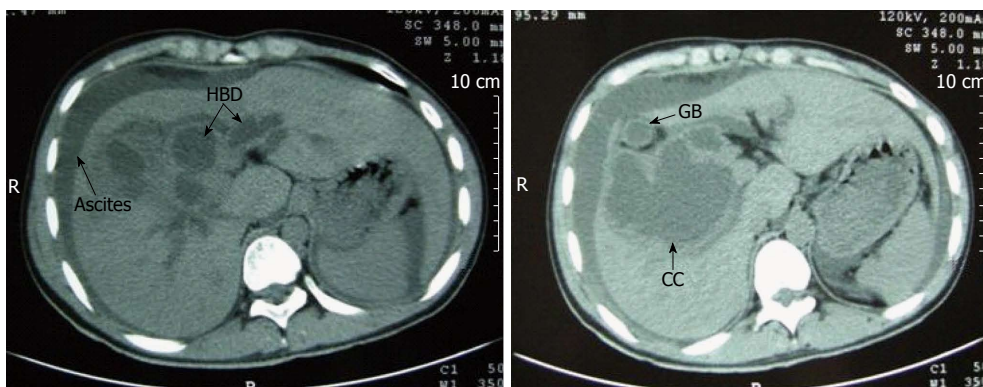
Abdominal computed tomography shows ascites, a normal-sized gallbladder, dilatation of the intrahepatic bile duct, and a huge choledochal cyst. GB: Gallbladder; HBD: Intrahepatic bile duct; CC: Choledochal cyst.
